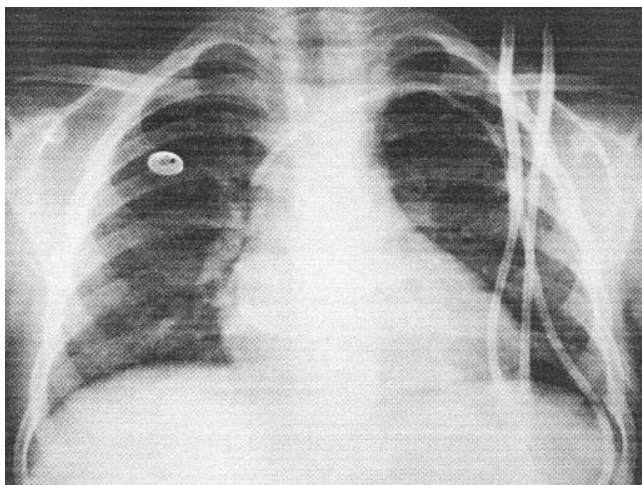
chest radiograph at the time of transplant (hickman line in position).
